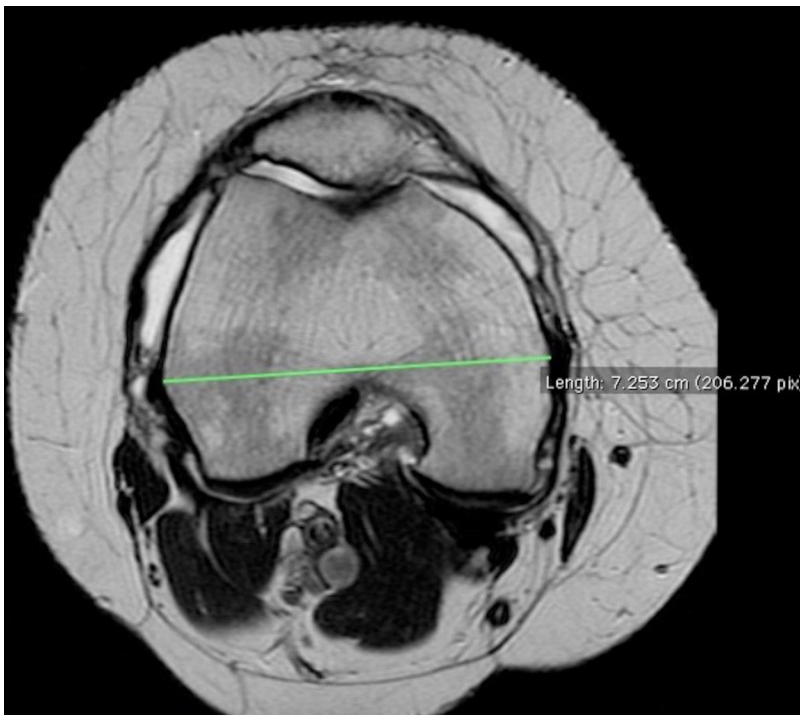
MRI measurement of the largest intercondylar line.
